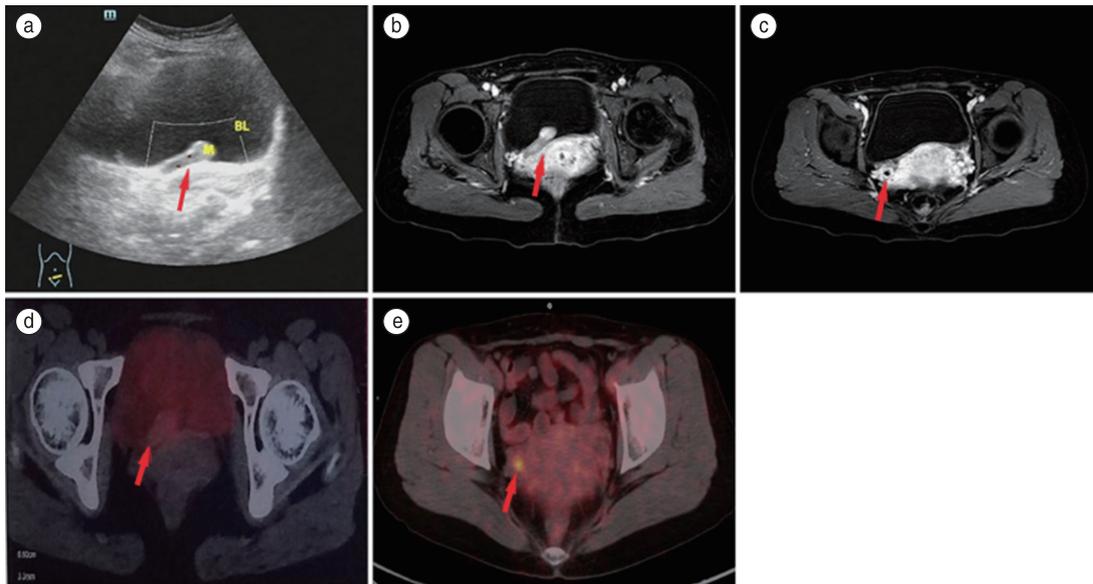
US, MRI and PET/CT images of tumor. (a) US image shows hypoechoic nodule can be seen in the triangle of the bladder, with regular shapes and clear boundaries; (b, c) Enhanced axial MRI images show abnormal signal shadow in the bladder triangle, thickening of the ureteral wall with dilation; (d, e) 18F-FDG PET/CT images show solid nodules in the right ureter and bladder triangle with increased radioactivity uptake. US, ultrasound; MRI, magnetic Resonance Imaging; 18F-FDG PET/CT, 18F-fluorodeoxyglucose positron emission tomography/computed tomography
